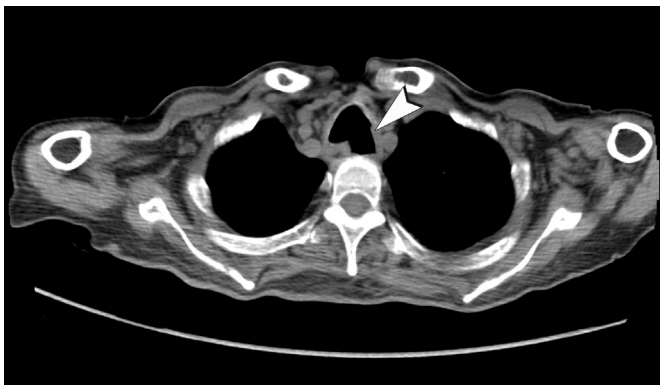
On CT examination Tracheomegaly and cuff of endotracheal tube in trachea and nasogastric tube were seen in Fig. 2, and fistula was seen Fig. 3 (arrow heads).
